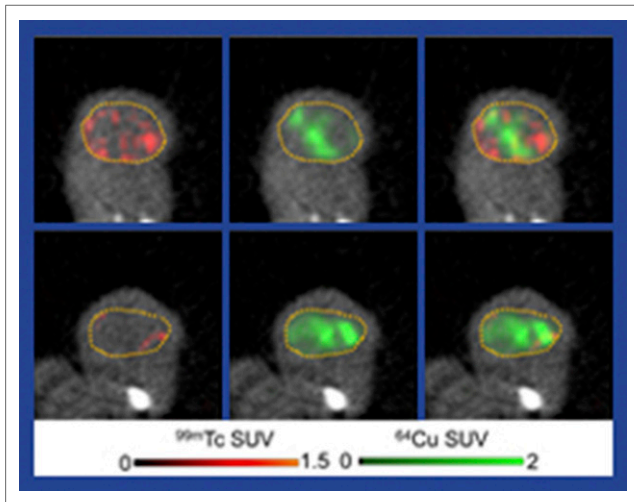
Characterization of bevacizumab-resistant tumors. SPECT/CT and PET/CT imaging with ^{99m}Tc -human serum albumin (left, blood pool) and ^{64}Cu -ATSM (middle, hypoxia). Right: fused images. Top: controls. Bottom: Bevacizumab-resistant tumor (after 3 weeks of bevacizumab treatment). Bevacizumab-resistant HT-29 tumors showed reduction of vascularity and increased hypoxic areas. The authors went on to study *in vivo* treatment with ^{64}Cu -ATSM + bevacizumab to target tumor angiogenesis and the induced hypoxia. The combination showed synergistic inhibition of tumor growth with minimal side effects.
